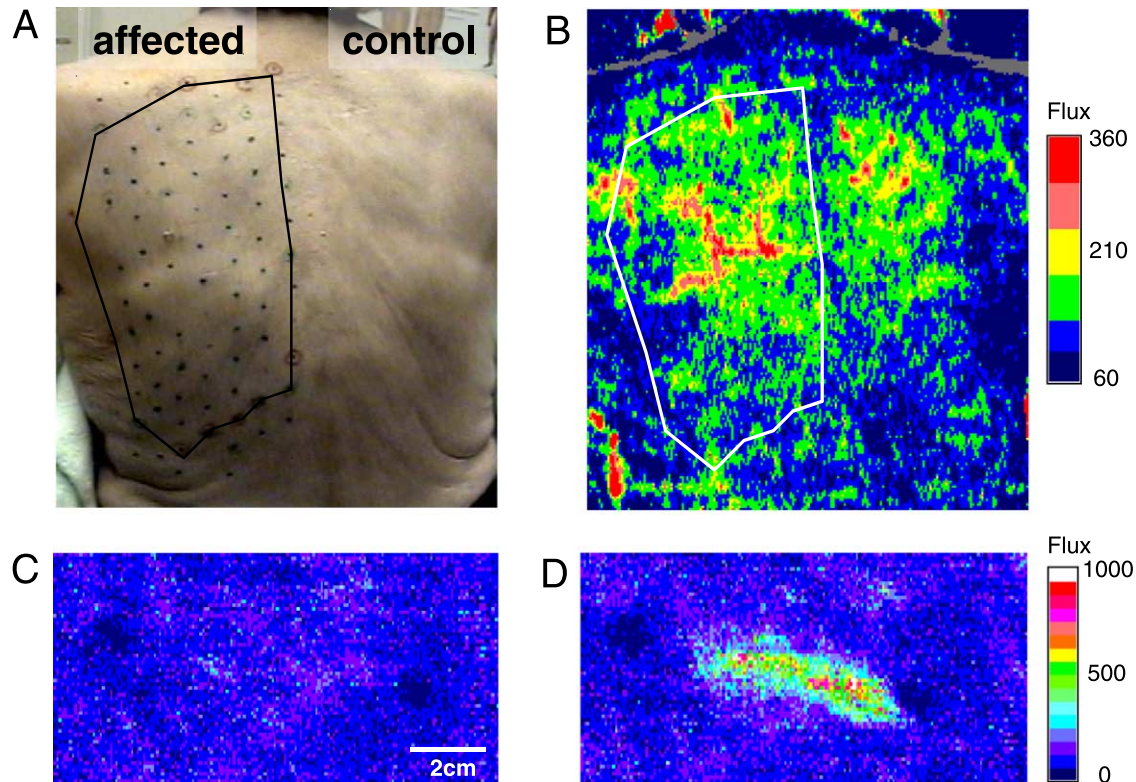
(A) Subject had shingles affecting the T4 dermatome some 16 years earlier. A grid has been marked with points at 2 cm intervals covering the painful area. The boundaries of the area of allodynia were defined (outlined) using a cotton bud to stroke the skin over each marked point. Stimuli were applied sequentially starting from a normal area and working into the affected zone. (B) Image of the baseline cutaneous blood flow over the subject's back using a laser Doppler imaging device (Moor LDI II). The skin blood flow is non-homogenous over the back with an increased flow in the affected area. (C) Skin blood flow image of an 11.6×4 cm area before and 1 min after (D) a gentle scratch with an orange stick showing a dramatic localised increase in flow associated with the flare response. Dark areas show location of skin markers.
